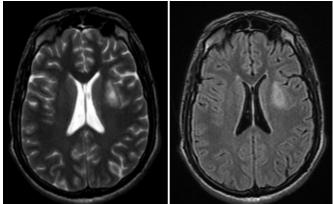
Abnormal Tumor-Like T2WI/FLAIR Hyperintense Signals seen in the Left Subcortical Region.
